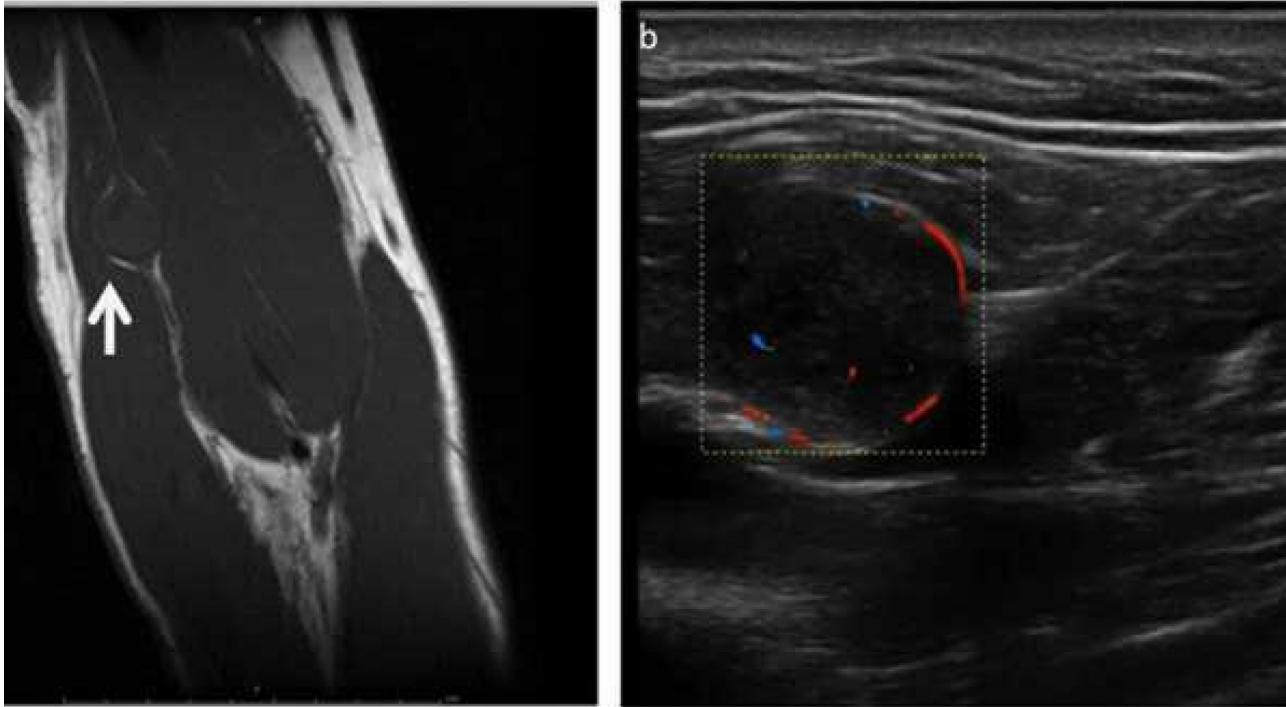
Nodular lesion localized between the muscles of the arm (arrow), at the radial neurovascular bundle: a) MRI imaging; b) US imaging: mass was subcutaneous although limited and homogeneous, ovoid and well encapsulated. Finally diagnosis with surgery biopsy: benign schwannoma.
